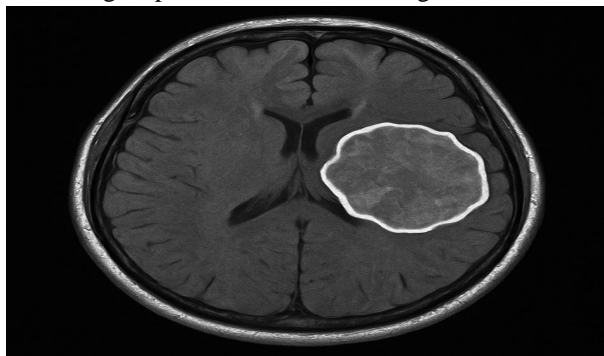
Axial brain MRI with the proposed algorithm’s segmentation of a right-hemispheric lesion. The outlined contour highlights the model’s ability to accurately identify and delineate the abnormal mass from the surrounding brain tissue
